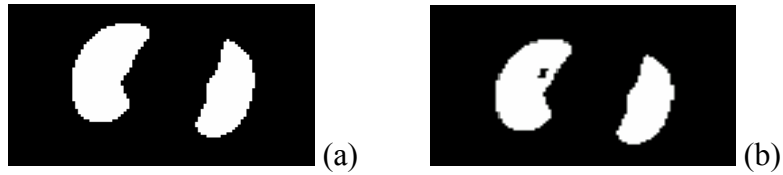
(a) binary templates of segmented CT lungs, (b) binary Templates of segmented lungs excluding tumor
